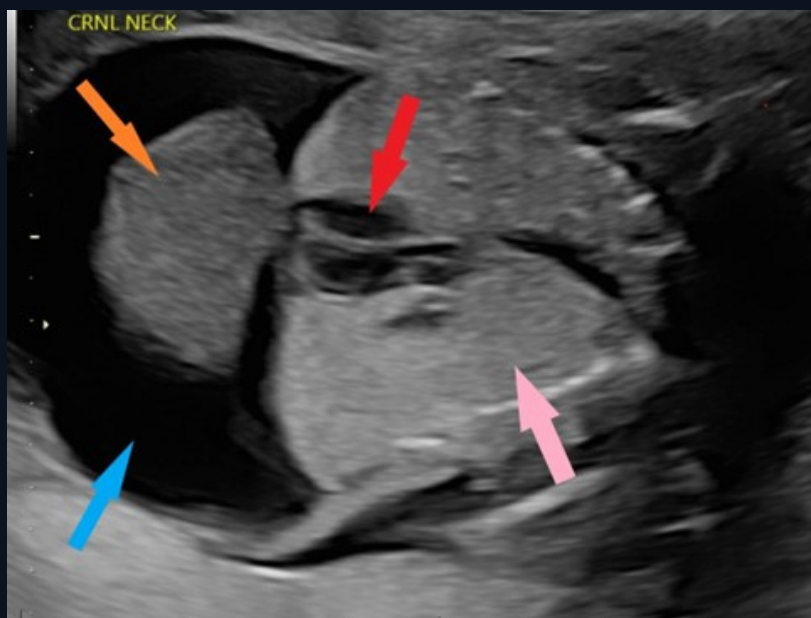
This coronal greyscale ultrasound image demonstrates the normal liver (orange arrow) surrounded by significant ascites (blue arrow). Additionally, the enlarged hyperechoic lungs (pink arrow) are visualized with resultant eversion of the diaphragm. The heart (red arrow) is midline and appears compressed.
